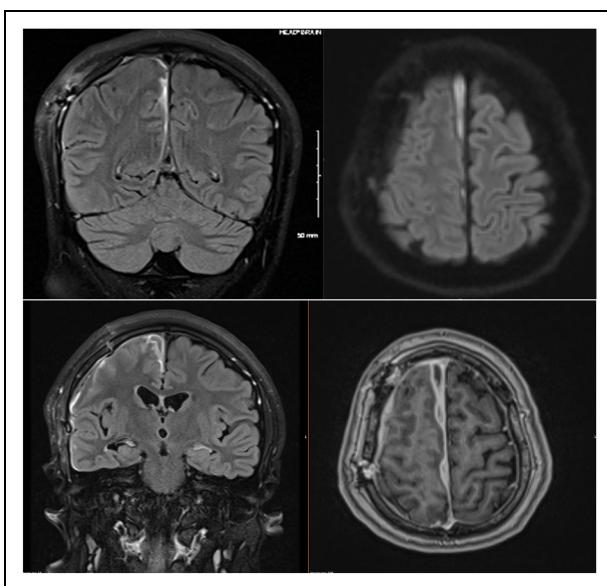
MRI T2 flair and DWI demonstrating hyperintensity in the right mesial frontal motor area.
